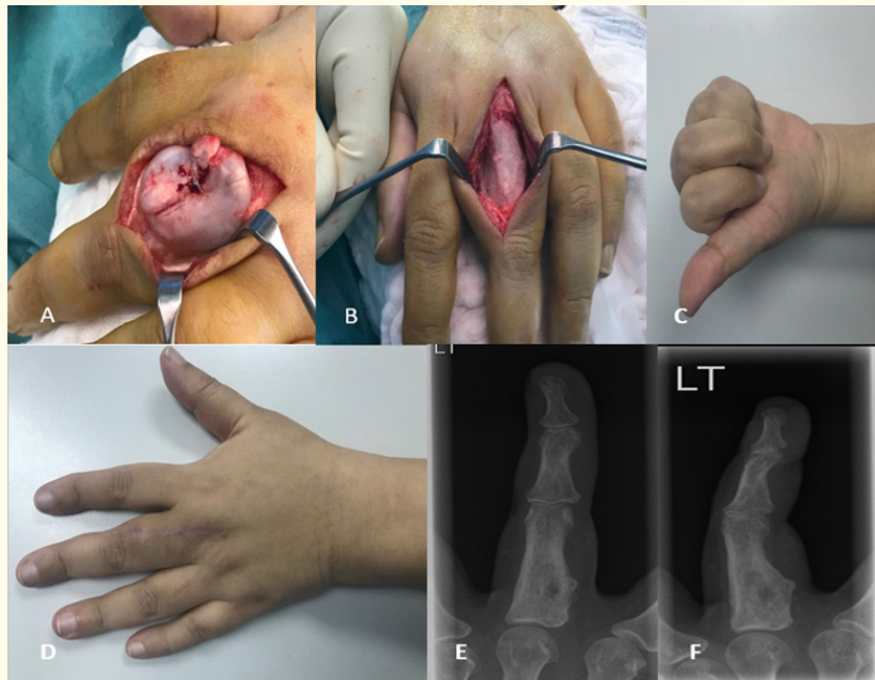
A: Intraoperative image shows the tumor with a thin capsule covering the soft tissue mass. B: Tumor resection and the bone surface covered with bone wax. C, D: Range of motion after two years post surgery with full flexion and extension. E, F: Radiographs two years post-surgery.
